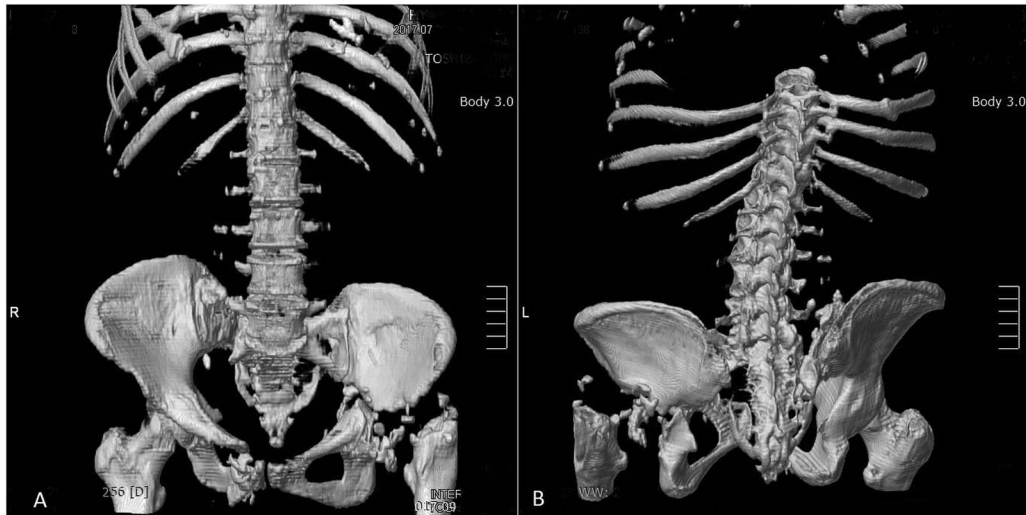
Pelvic 3D-constructed CT: (A) anterior section. (B) Posterior section. Both sections show a complete absence of the left femoral head.
